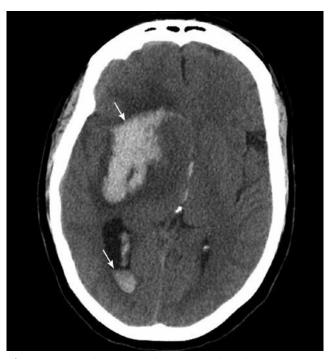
Head computed tomography showing intracerebral hemorrhages (*arrows*).
